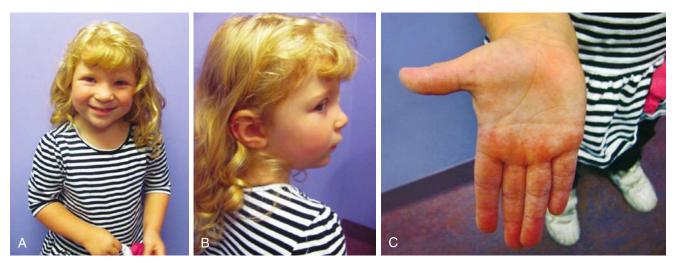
A female, 3 years and 8 months old, with double aneuploidy: aneuploidy depicted by cytogenetic studies. Karyotype and FISH studies show predominantly 47XXX; some 47XXX also have an extra 21 (48XX+21). The patient has some features of Down syndrome. Note the up-slanted palpebral fissures (A), low-set ears (B), and unilateral simian crease (C). An echocardiogram showed a patent foramen ovale. The patient is receiving behavioral and speech therapy; she is not toilet trained and has an individualized education program (IEP) in preschool. Triple X females are tall and mosaic Down syndrome is similar to full Down syndrome but with a much milder phenotype. Her weight was in the 95th percentile, her height in the 80th, and occipital–frontal circumference (OFC) in the 20th.
